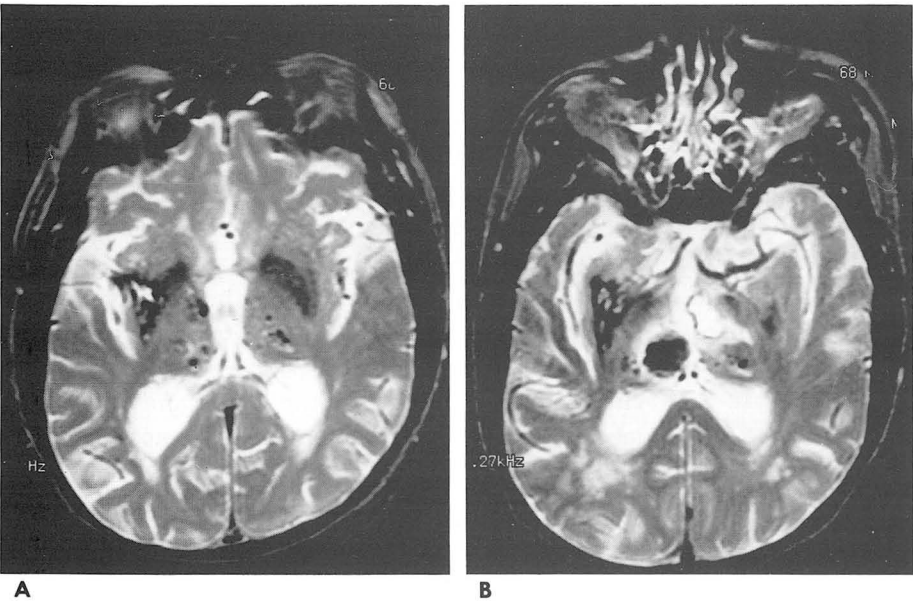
T2-weighted images of a 68-year-old man with repeated hypertensive hemorrhages.
